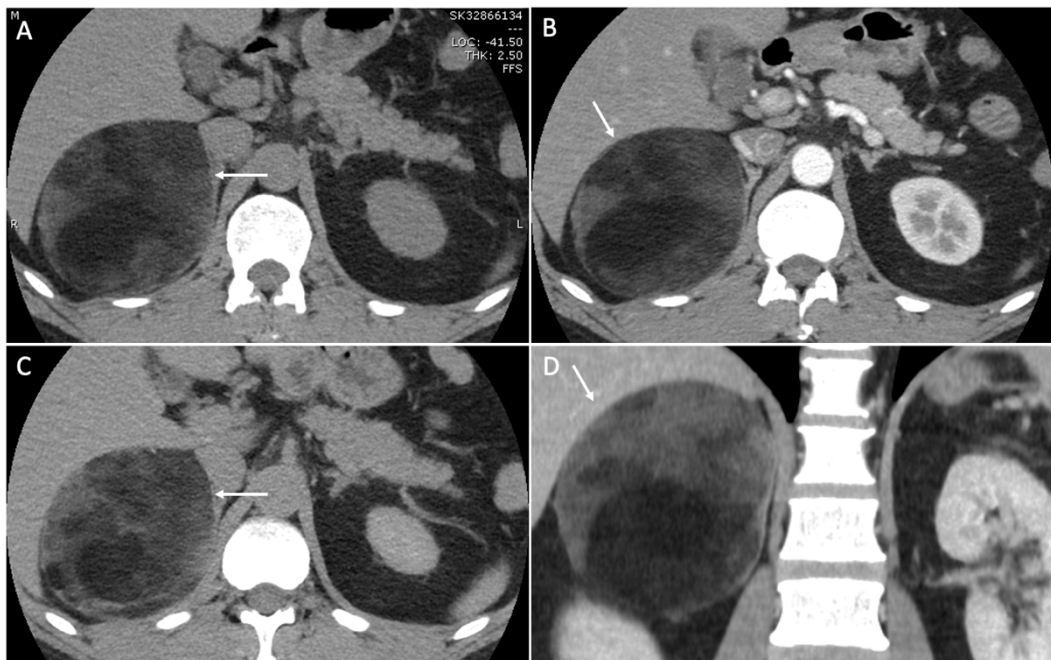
Axial precontrast (A), Arterial phase (B), Delayed phase (C), and Coronal delayed (D) CT images reveal a well-defined right adrenal lesion (Arrow).
